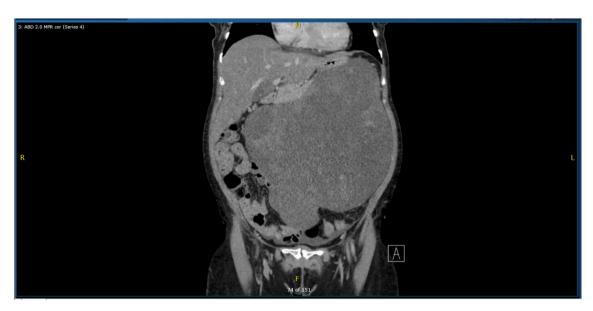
Abdominal computed tomography (CT) Coronal view showed a  $24.7 \times 23.5$  (cm) retro-gastric tumor.
